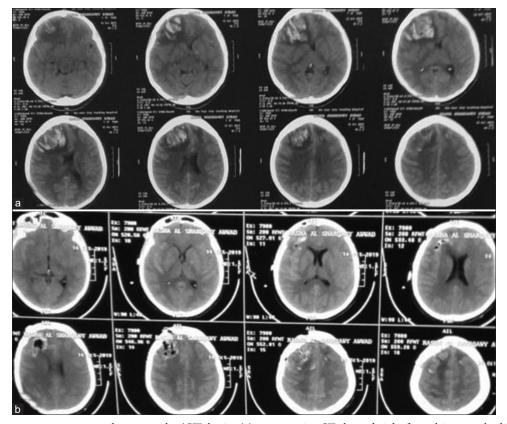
Case 1, noncontrast computed tomography (CT) brain. (a) preoperative CT showed right frontal intracerebral hemorrhage with compression of ipsilateral frontal horn and midline shift. (b) postoperative CT brain. Decompression of the mass effect exerted by the hematoma with pneumocephalus in the bed of surgical site.
